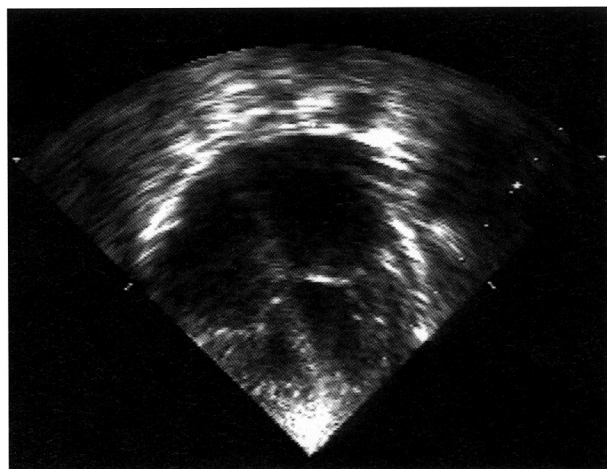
Apical four-chamber view of two-dimensional echocardiography shows marked biatrial enlargement.
